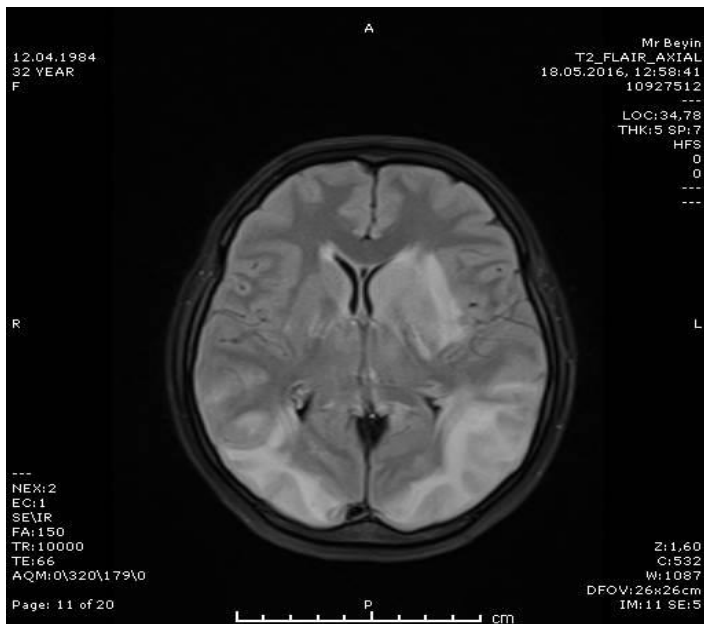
Hypointense lesions on FLAIR sections
